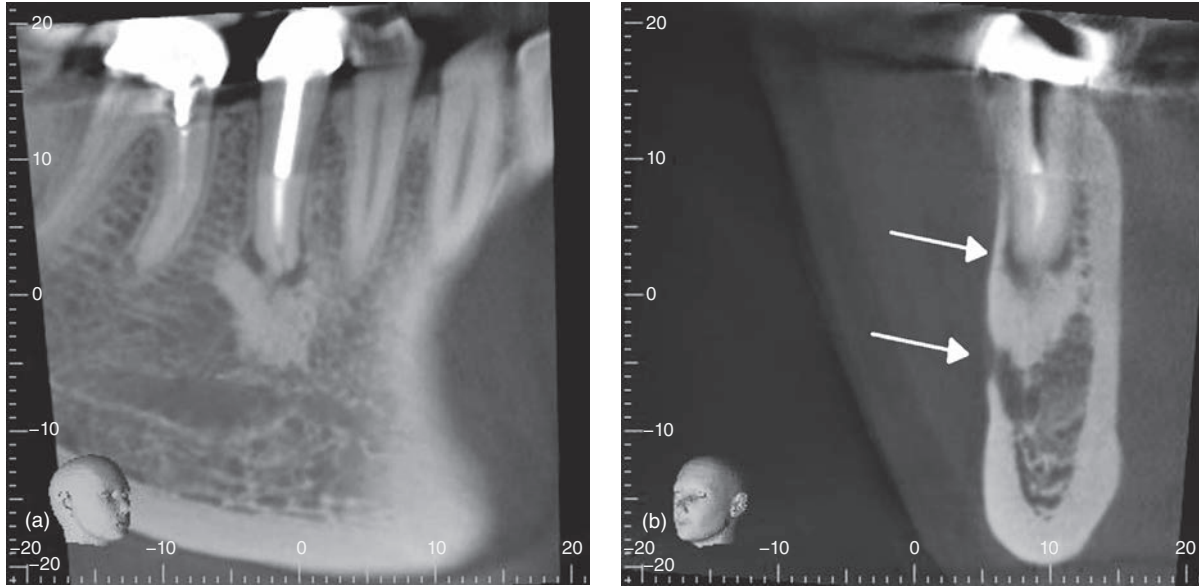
CBCT of #29. (a) Clear view of the mental foramen. (b) Arrows point to the apex of the root and the mental foramen. This distance is average.
